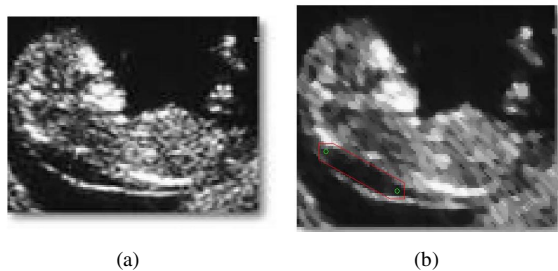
The NT's initial contour (b) for a fetal ultrasound image (a).
